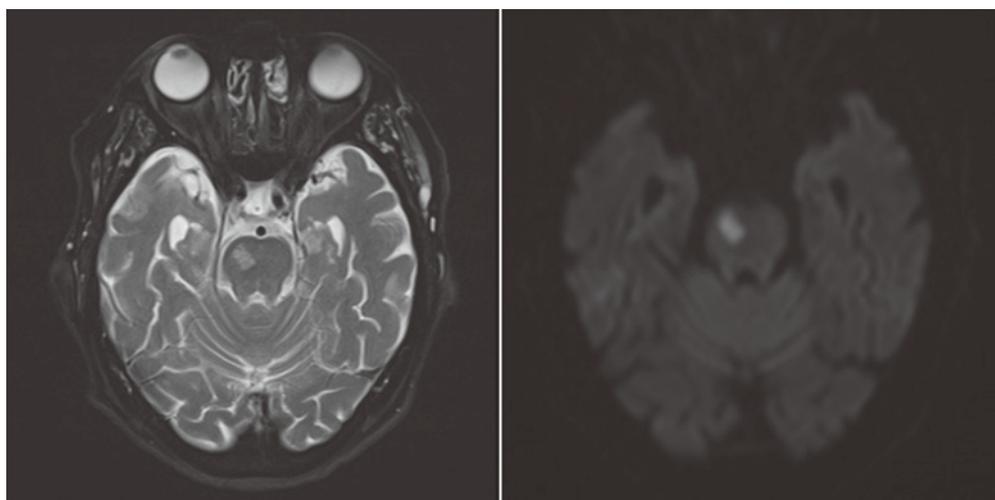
Magnetic resonance imaging of the brain reveals an acute ischemic stroke in the right ventral pons.
